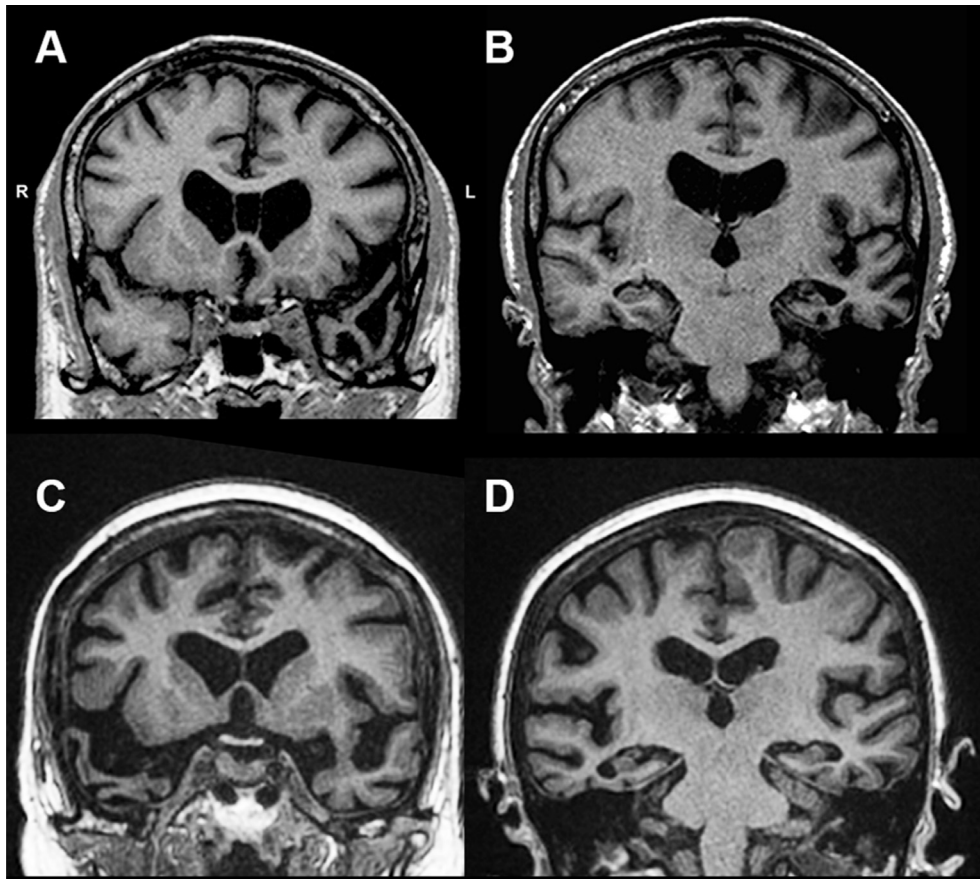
T1-weighted coronal MR images in radiological orientation showing temporal lobe atrophy: A) anterior temporal left > right, B) posterior temporal left > right, C) anterior temporal right > left, D) posterior temporal right > left.
